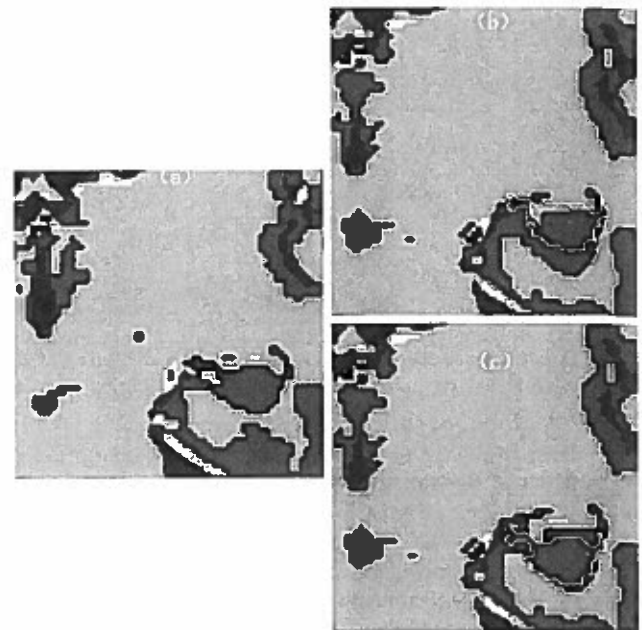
(a) Segmented hippocampal region of slice 7 of 13 from MRI series, with final contour shown in black. (b) Hippocampal region of slice 8. Initial contour, passed without motion estimation from slice 7, shown in white. Final contour shown in black. (c) Hippocampal region of slice 8. Initial contour, passed with motion estimation from slice 7, shown in white. Final contour shown in black.
